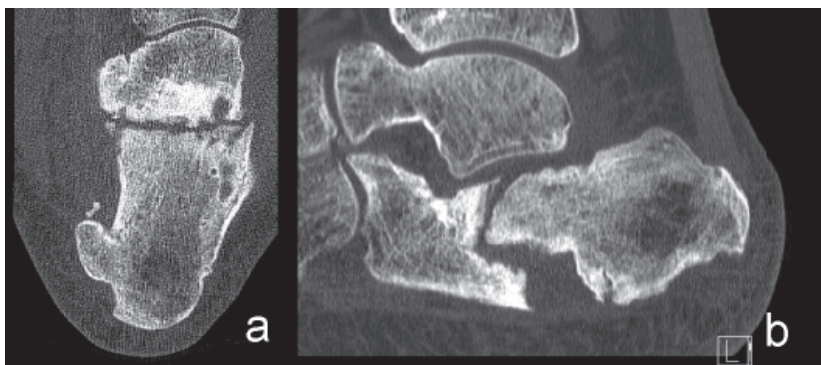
a, Case 3: Semi-coronal CT-scan image 13 months after conservative treatment showing nonunion; b, Sagittal view.
